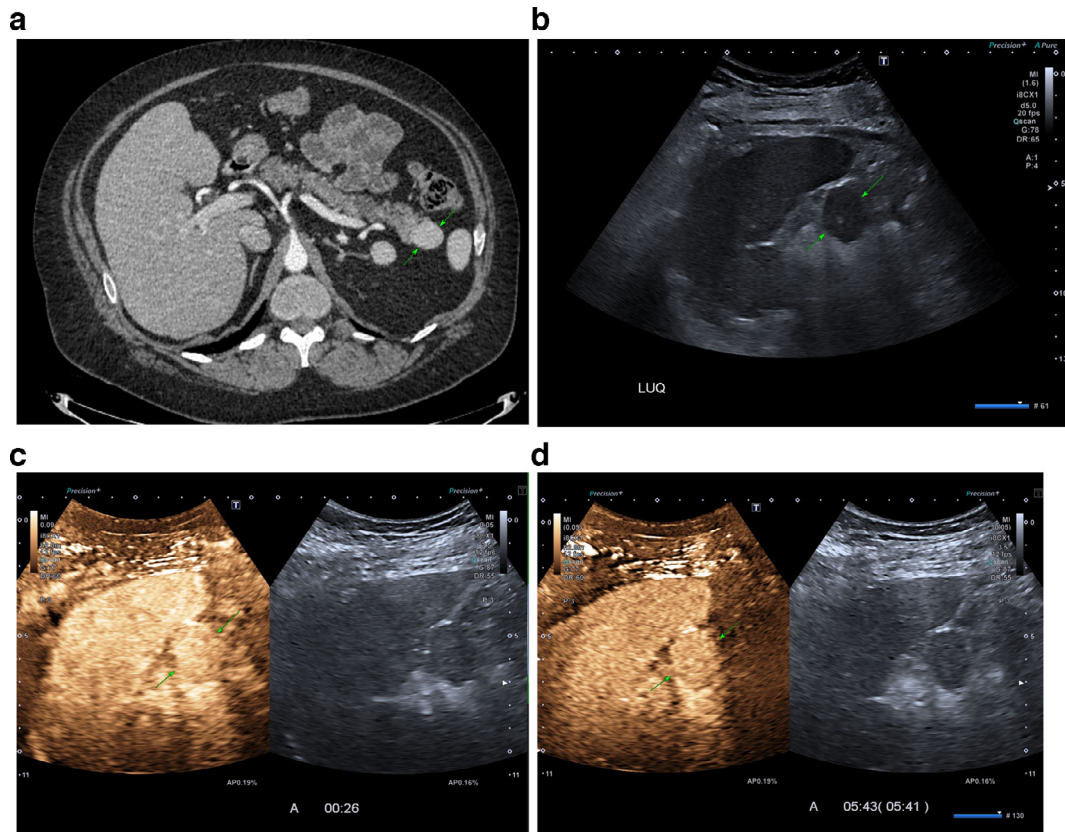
Pancreatic tail splenunculus. Image from a CT urogram examination in a 56 year old man undergoing investigation for visible haematuria. A small incidentally discovered hypervascular mass is present in the pancreatic tail (a, arrows). The mass is visible on ultrasound with echogenicity identical to the adjacent spleen (b, arrows). Following injection of ultrasound contrast microbubbles the mass enhances in an identical manner to adjacent splenic parenchyma in the arterial (c, arrows) and late phases (5 minutes 41 seconds post injection, arrows (d)). Equivalent enhancement to splenic parenchyma and persistent late phase enhancement are characteristic features of ectopic splenic tissue.
